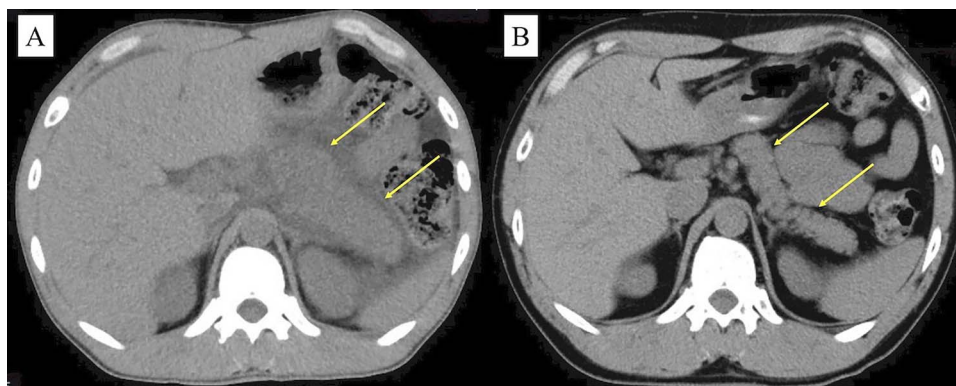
(A) Abdominal CT obtained at admission shows diffuse swelling of the pancreas (arrow). (B) Abdominal CT shows improvement of the diffuse swelling of the pancreas after corticosteroids therapy (arrow).
